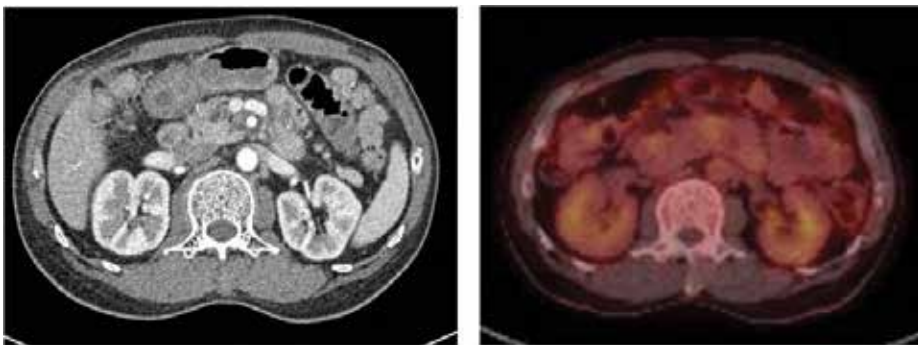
CT and PET scan of pancreatic cancer post-brachytherapy.
